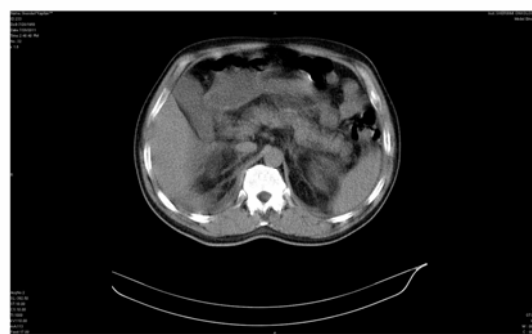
Abdominal CT. Peritoneal liquid and edema of the pancreas and peripancreatic tissues.
